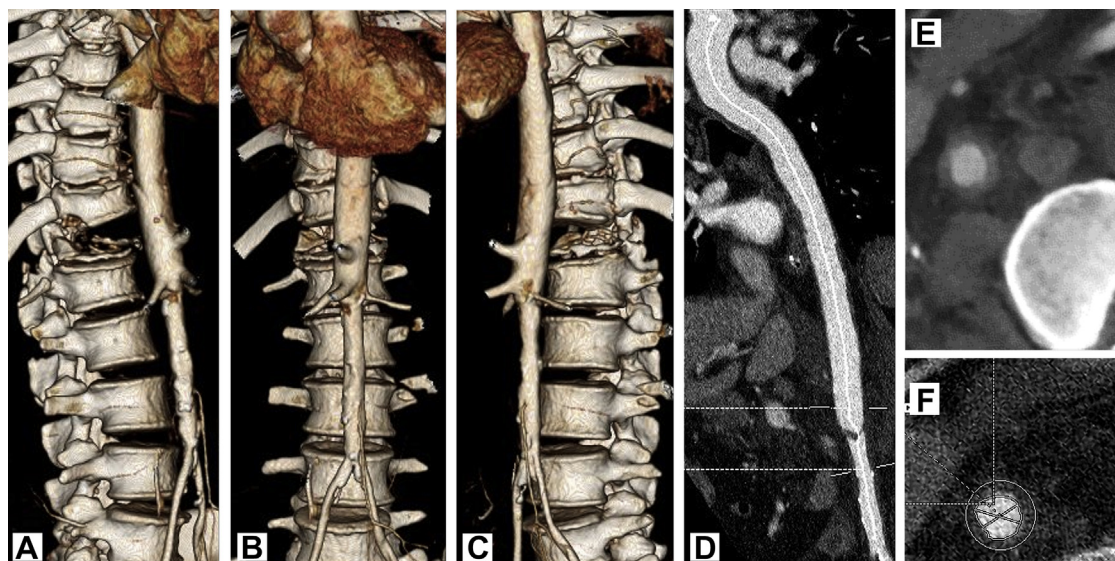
A-C, Three views of a three-dimensional reconstruction of the aortic injury, highlighting the drop-off in aortic diameter and extensive bone spinal injuries (anterior dislocation of the T12 vertebral body, T12-L1 bilateral facet fractures and dislocation, and L2-L3 transverse process fractures). D, Sagittal view of computed tomography angiography (CTA) image used to construct the three-dimensional figures demonstrating the intimo-intimal defect. E and F, Zoomed in axial views of the circumferential dissection.
